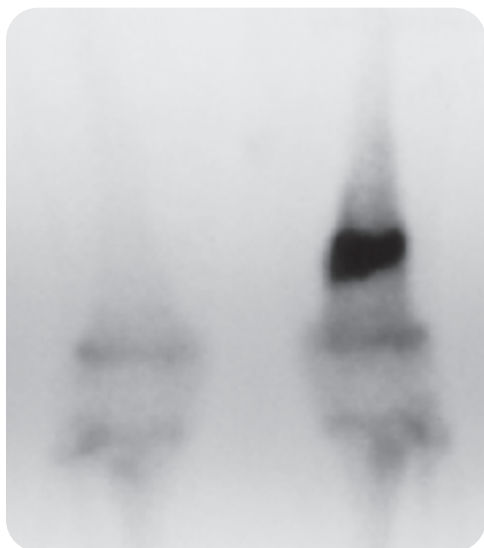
Radionuclide scintigraphy. Bone scans can detect stress fractures long before the fracture becomes visible on traditional radiographs. This individual had increased his daily run from 5 to 8 miles per day and included hill climbing over the past few months. He reported increasing pain in his thigh. The bone scan showed increased density in a transverse line, indicating medial periosteal reaction.
